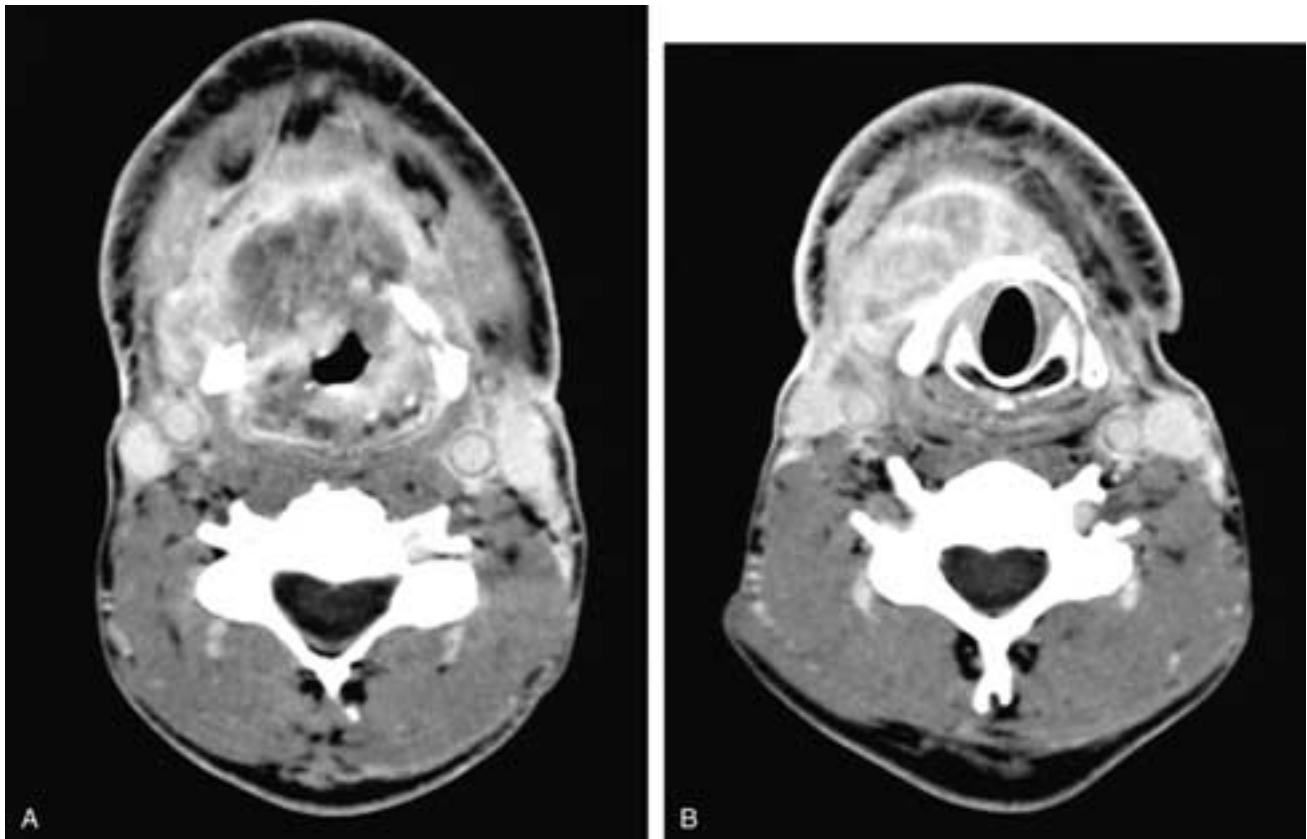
Axial contrast-enhanced CT scans from cranial (A) to caudal (B) in a patient who has had a supraglottic laryngectomy and bilateral modified neck dissections (IJVs are present). There is an extensive recurrence of squamous cell carcinoma throughout the operative bed extending from the pharynx into the base of the tongue and the floor of the mouth. The tumor then extends caudally (B) into the strap muscles and anterior neck.
